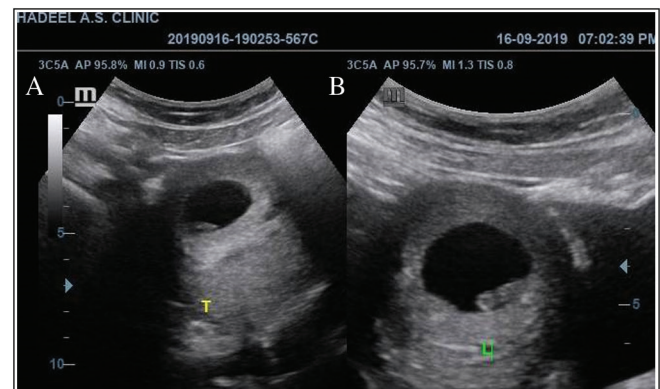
(A) Ultrasound examination at transverse view of gestational sac showed chorionic villi on left inferiolateral side of sac. (B) Anterior location of chorionic villi at longitudinal view of ultrasound image
